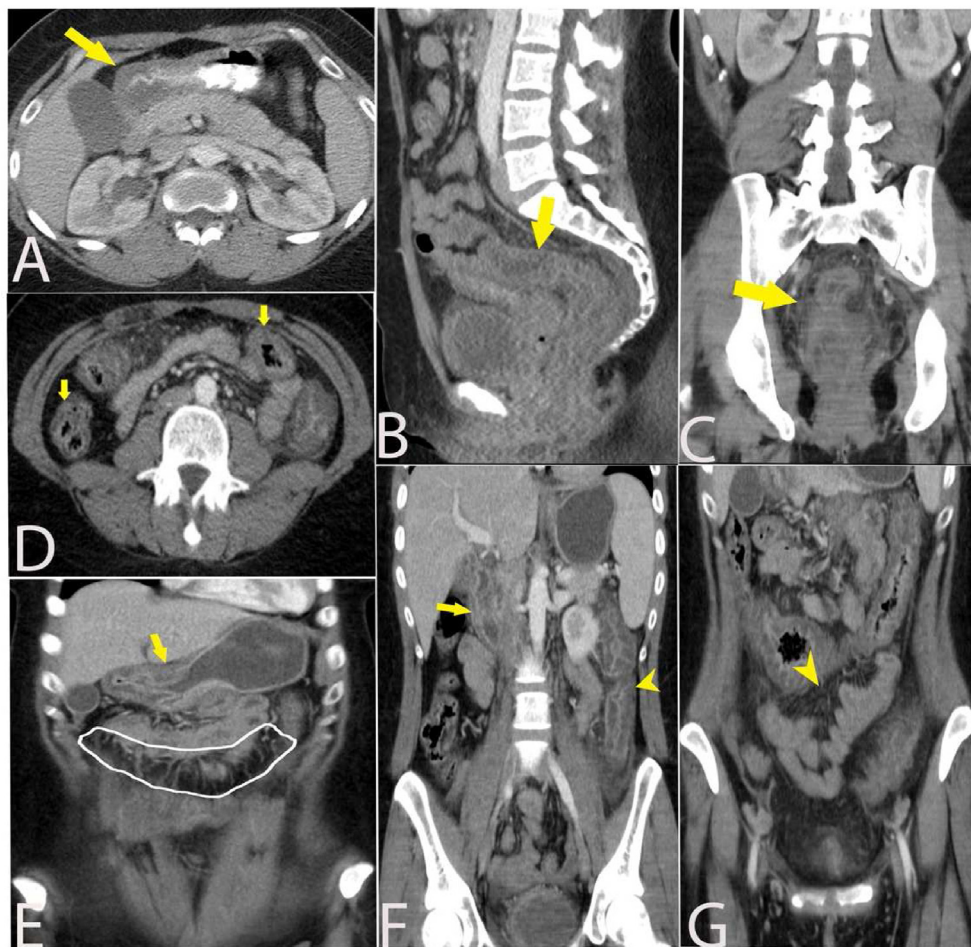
Patient with a history of systemic lupus erythematosus presenting with abdominal pain. CT of the abdomen and pelvis with iodinated intravenous contrast shows diffuse circumferential wall thickening and edema of the gastric wall (arrow, A), most prominent at the pylorus. There is mild diffuse circumferential wall thickening of the colon prominent at the rectosigmoid region (arrow, B) with peri colonic fat stranding (arrow, C) and small ascites. CT with iodinated IV contrast performed eight months later for abdominal pain again shows similar findings, including diffuse wall thickening and edema involving the stomach (arrow, E), duodenum (arrow, F), and colon (arrowhead, F), including rectosigmoid. Colonic wall thickening with mucosal hyperenhancement, known as the “target sign,” is visualized (arrows, D). Diffuse mesenteric edema and engorgement, known as the “comb sign” (highlighted in white, E and arrowhead, G) with small ascites, is noted.
